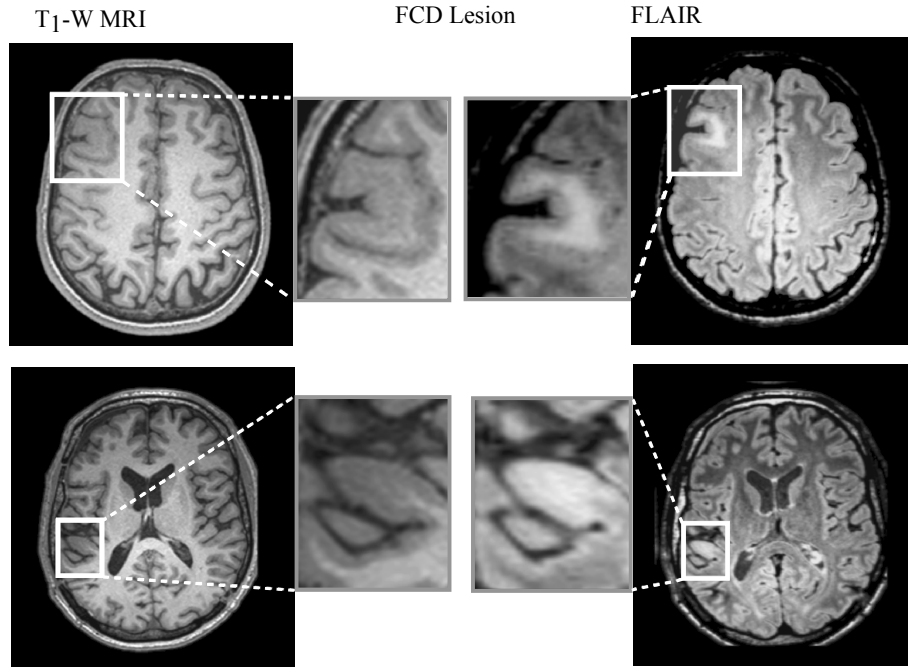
FCD lesion on T_1 -W and Core Flair MRI. By integrating both MRI modalities in a segmentation framework can improve the FCD lesion detection.
